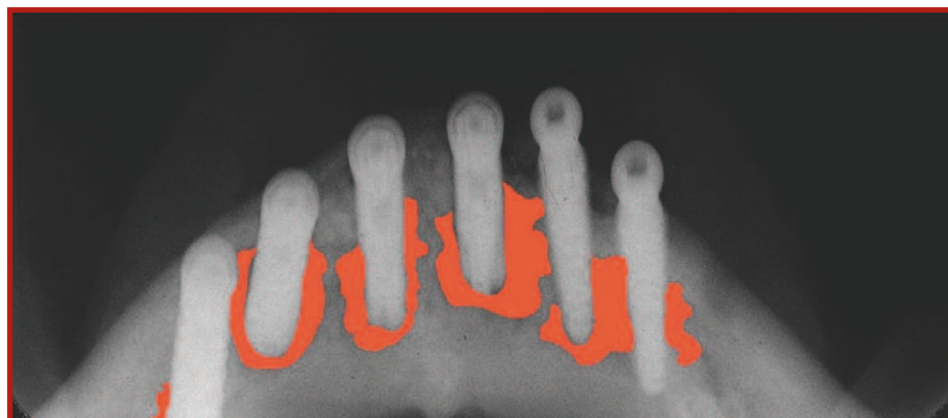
Post-operative occlusal radiograph after implant placement showing illdefined highlighted radiolucent areas.
